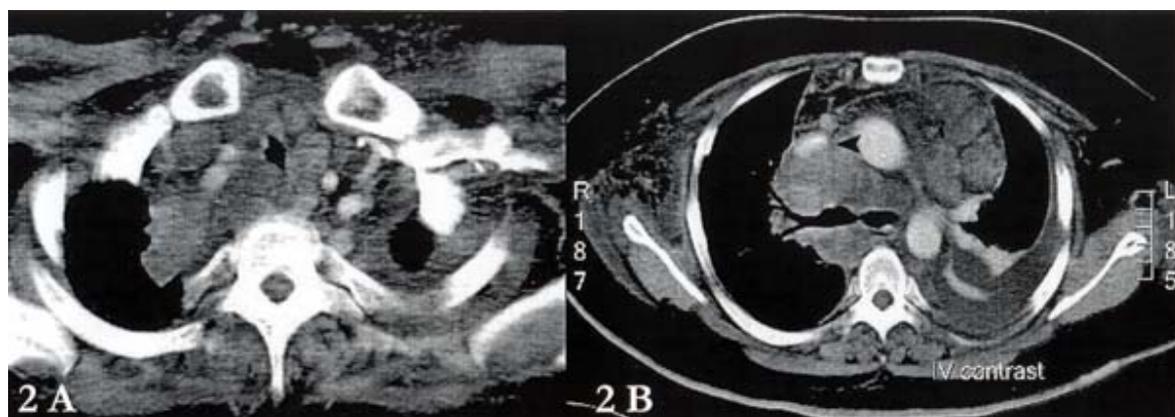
(A) CT scan of the chest showed matted paratracheal lymph nodes causing trachea narrowing. (B) Enlarged mediastinal lymph nodes caused SVC compression (arrowhead)
